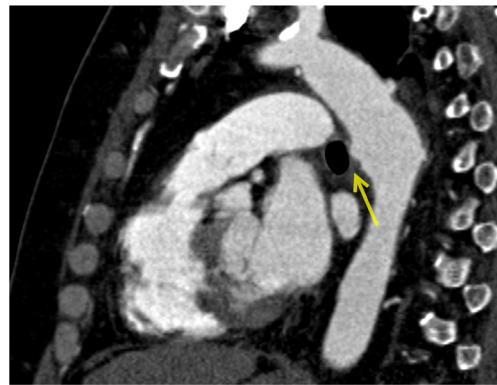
Sagittal CT image demonstrating effacement of the plane between the left mainstem bronchus and thoracic aorta (arrow) with a focal contour deformity of the aortic wall. Of note, this is not a ductus diverticulum as it arises distal to the left subclavian artery origin. This is a case of aortobronchial fistula
